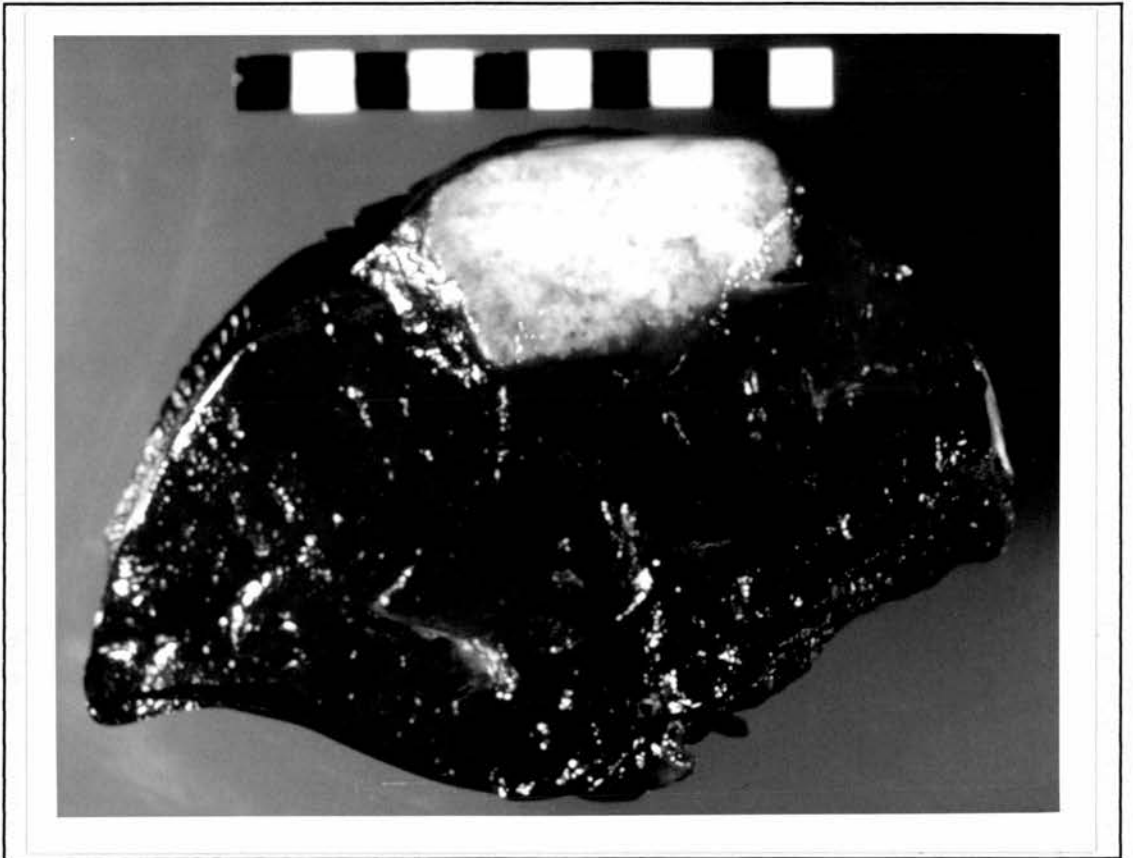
A large, solitary metastases detected by ultrasound, CT scanning and palpation prior to resection.
